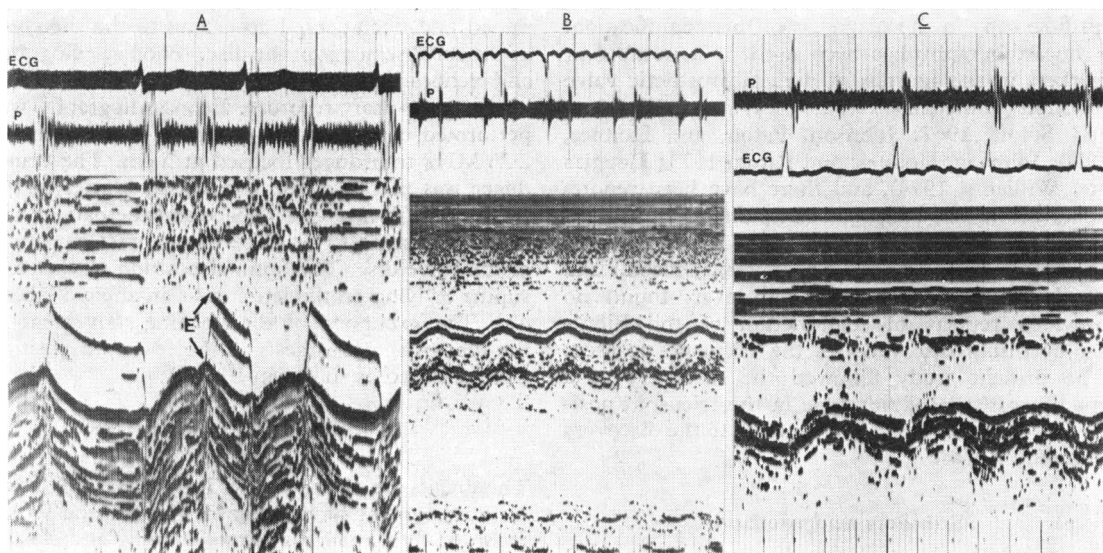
Echocardiograms of tricuspid valve prostheses. (A) Functioning prosthesis in Case 3; disc excursion (E) was measured between the two black arrows. (B) Stuck prosthesis in Case 1. (C) Stuck prosthesis in Case 4. P=phonocardiogram.
